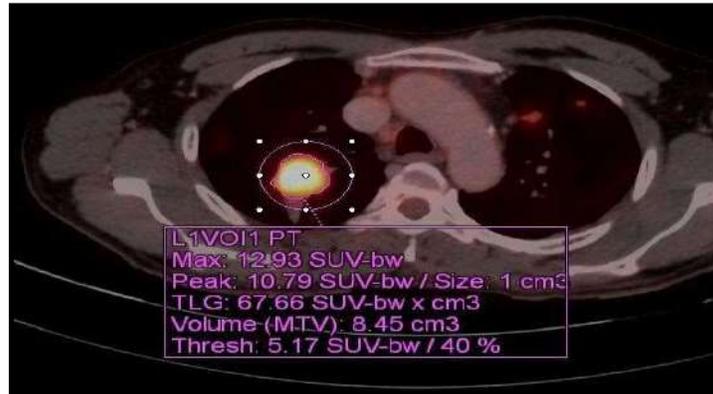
Selection of ROI for analysis of FDG-PET parameters
